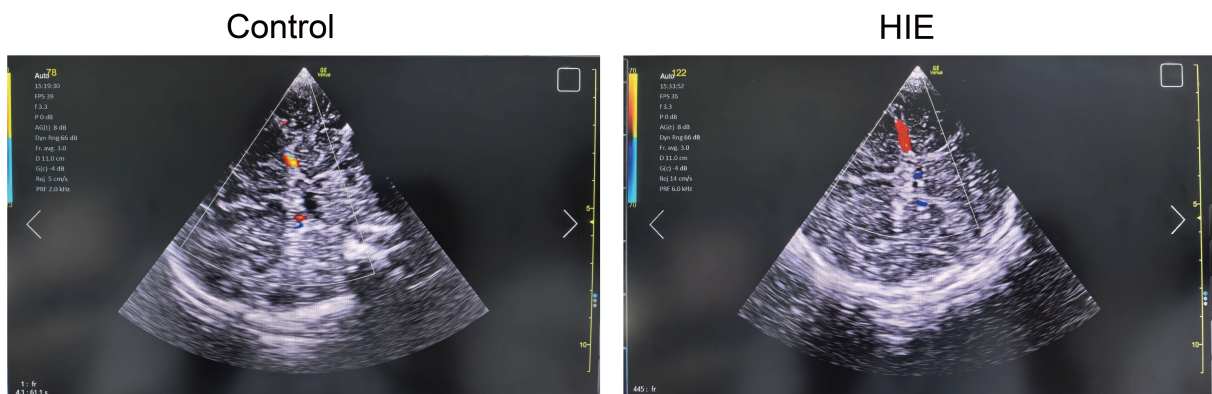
Representative color Doppler ultrasound images of the middle cerebral artery in the control and HIE groups. Color Doppler ultrasound (CDU) images show cerebral blood flow in the middle cerebral artery (MCA). (Left) The control group demonstrates normal flow velocity and uniform color filling, indicative of normal cerebral perfusion. (Right) Neonate with hypoxic-ischemic encephalopathy (HIE) exhibits reduced flow velocity, decreased color signal intensity, and abnormal flow distribution, consistent with impaired cerebral perfusion and increased vascular resistance.
